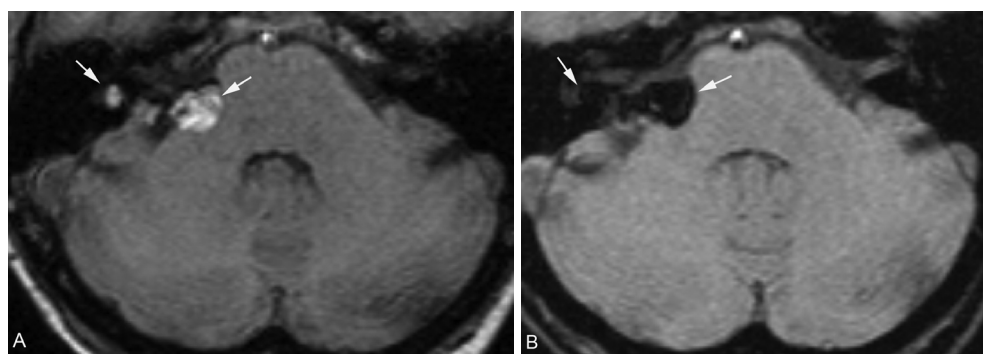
Magnetic resonance imaging scans of the infratentorial region. A, Axial conventional (nonenhanced) T1-weighted and (B) fat-suppressed T1-weighted scans. In the right cerebellopontine angle and the right vestibule, 2 lesions (white arrows) with marked intrinsic hyperintense signal on the nonenhanced T1-weighted image (A) are seen. The hyperintense signal on T1-weighted imaging is completely suppressed after applying a fat-suppression inversion pulse (B).
